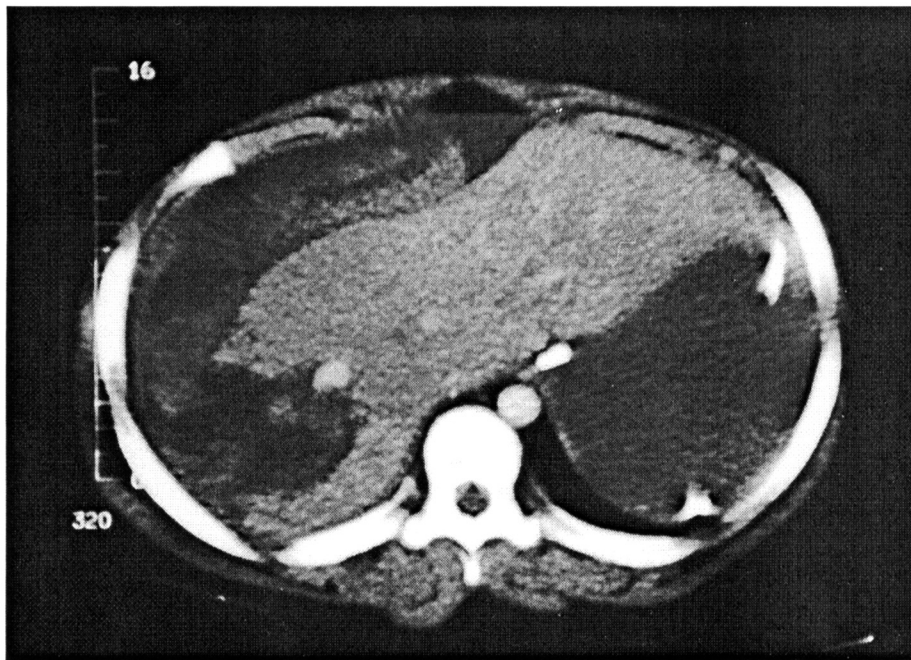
CT scan on postoperative day 15 with large subcapsular hematoma with contrast extravasation.
